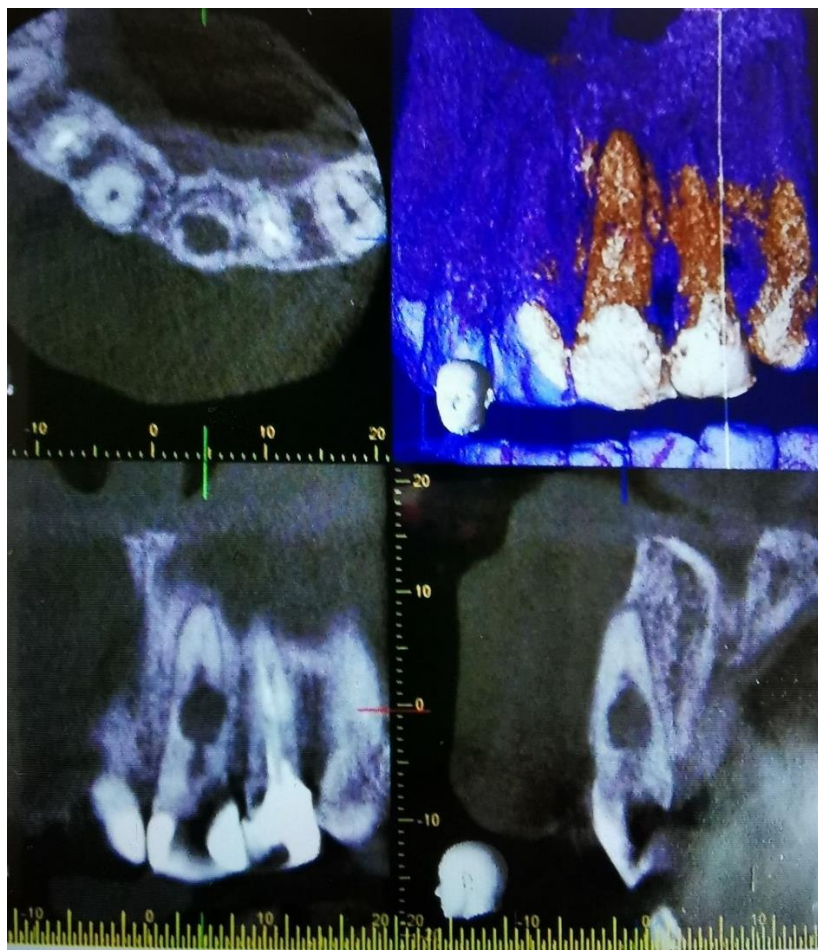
Internal root resorption of tooth 21. CBCT is preferable to exclude root perforation
